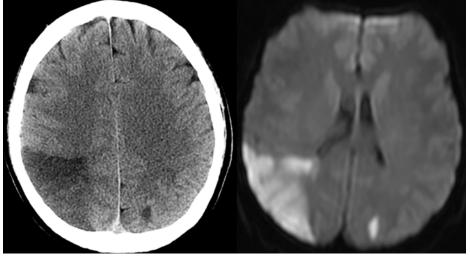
Subacute non-contrast computed tomography (left) and diffusion-weighted magnetic resonance imaging (right) from patient #4 with bihemispheric strokes.
